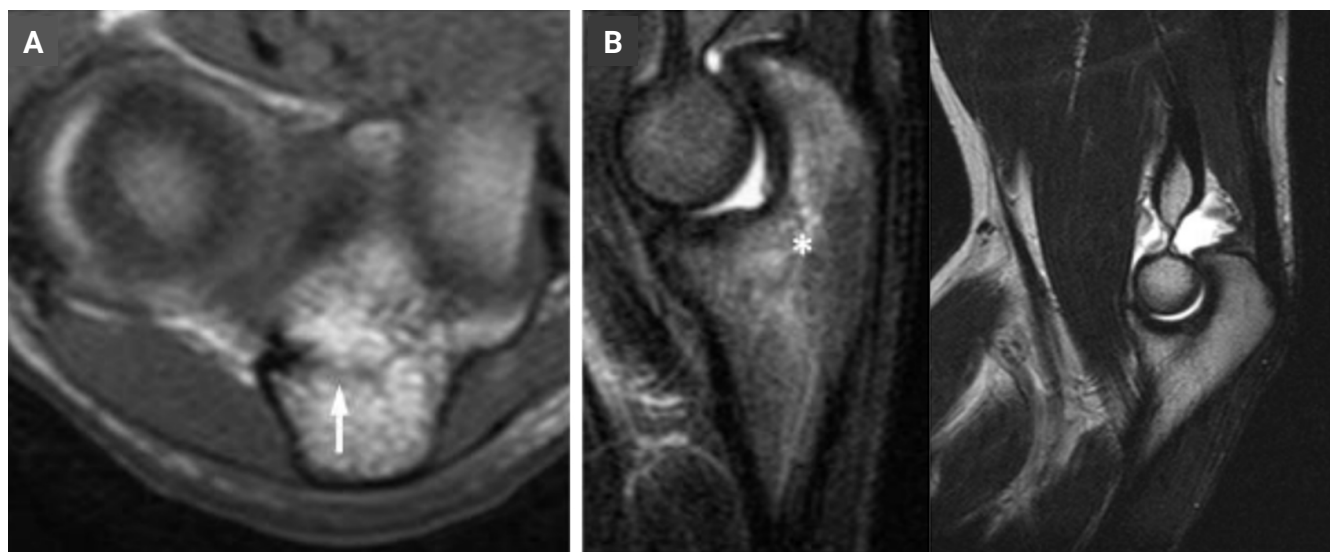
Magnetic resonance imaging (MRI) scans are particularly useful for evaluating symptomatic posterolateral impingement of the elbow. (A) T1W axial MRI shows a linear low-signal fracture line (arrow) traversing the olecranon. (B) Short inversion-time inversion recovery sagittal MRI image shows increased signal (asterisk) corresponding to marrow edema in the olecranon.
